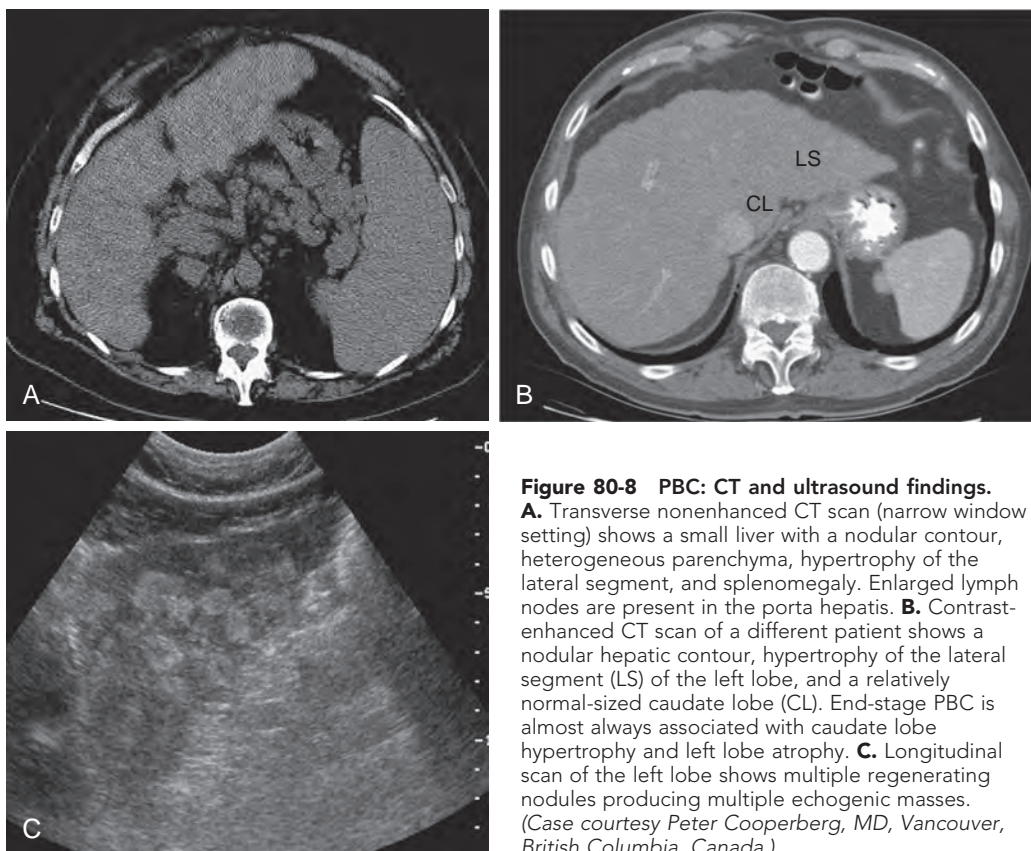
PBC: CT and ultrasound findings.
